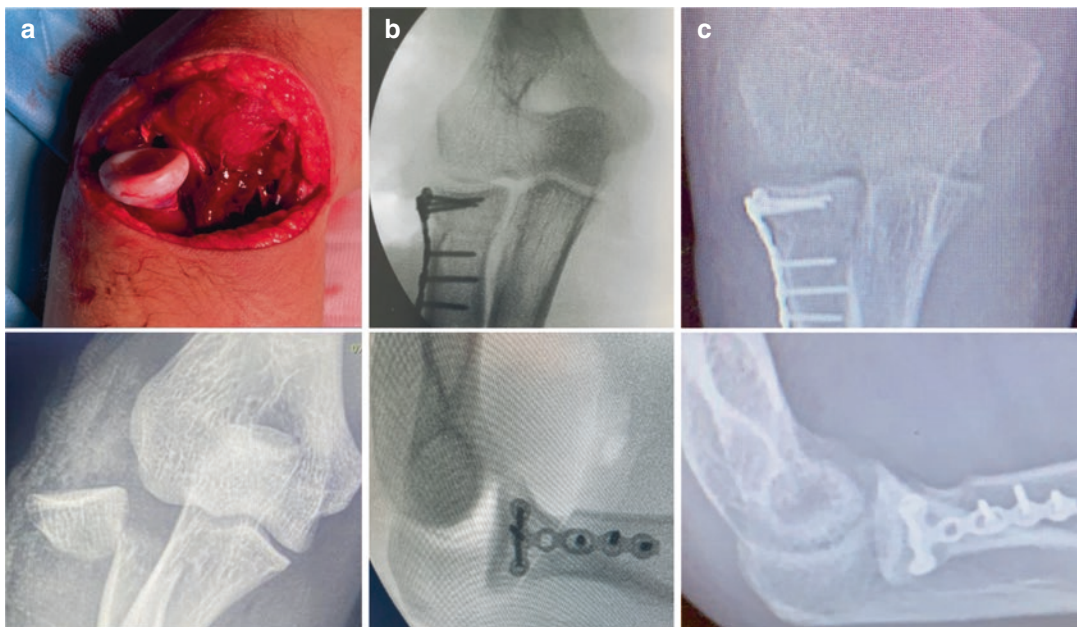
(a) Traumatic open radial head fracture treated with open reduction and internal fixation (ORIF); (b) anteroposterior (AP) and lateral intraoperative fluoroscopic control; (c) AP and lateral radiographs at 6 months
